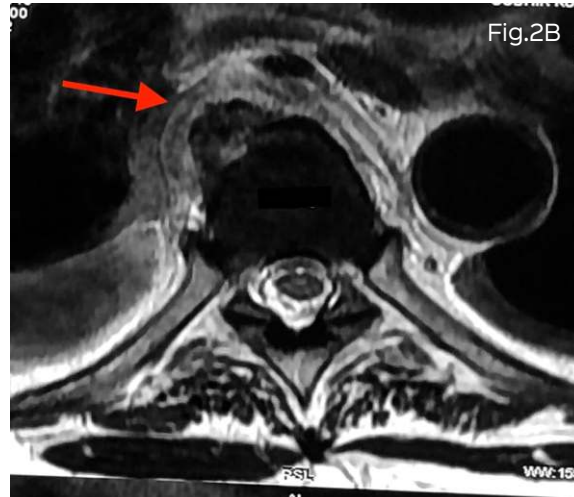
(A-D): MSSA infectious spondylitis D6/7. Sagittal T1W (A) MRI shows a discovertebral lesion with marrow edema at the D6/7 level (arrow) with abnormal perivertebral soft tissue and new bone formation, right more than left on the axial T2W image (arrow). The sagittal PET/CT shows the end-plate erosions and abnormal uptake (arrow), which was then biopsied (D).
